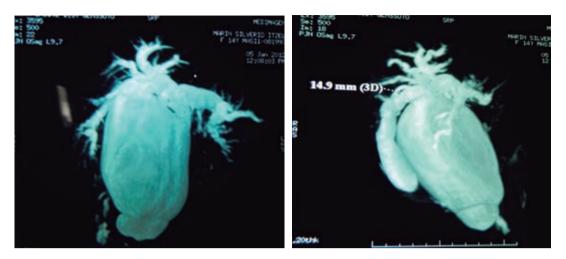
MRI cholangiopancreatography showing a giant common bile duct cyst type I.
